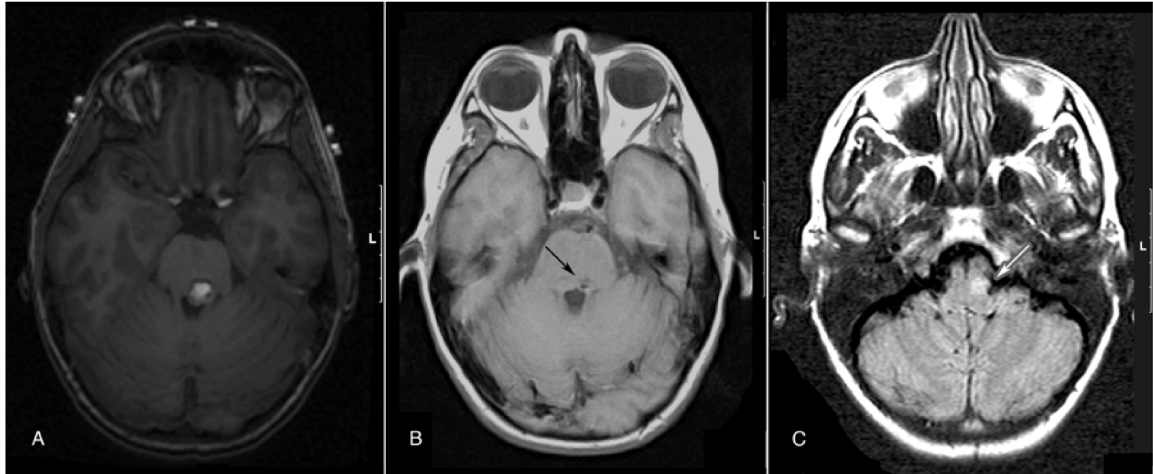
MR imaging scans of patient 2. (A) Axial, unenhanced, fat-suppressed T1-weighted MR image demonstrates preoperative location of cavernous malformation within the left dorsal pons. (B) Axial, unenhanced T1-weighted MR image obtained 17 months postoperatively demonstrates the unremarkable changes in the resection bed (arrow). (C) Postoperative axial FLAIR MR image shows increased signal intensity in the left lateral medulla with an enlargement of the olivary nucleus (arrow) compared to the contralateral side; left, unilateral HOD.
